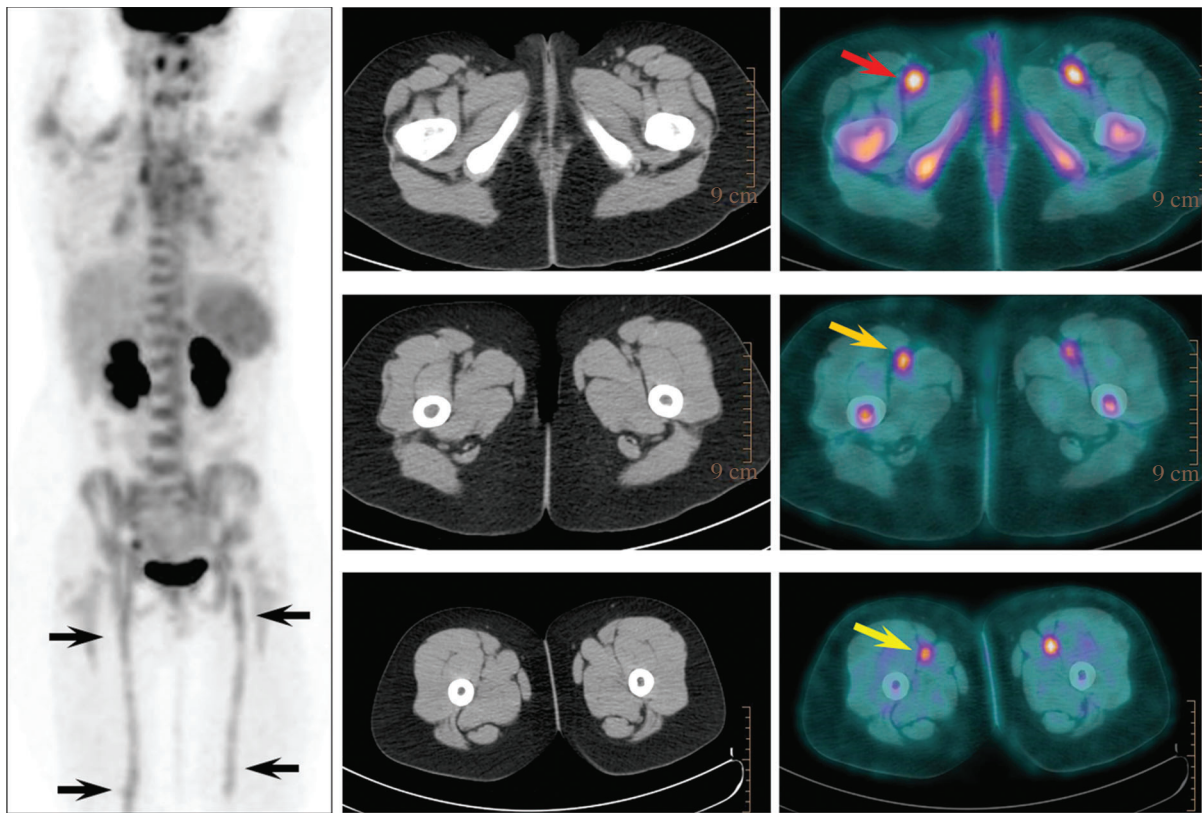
FDG PET-CT images of a teenager with fever of unknown origin. Linear FDG activity in both legs seen on maximum intensity projection (MIP) images (black arrows, left panel) localized to proximal (red arrow), middle (orange arrow) and distal (yellow arrow) femoral arteries on fused PET-CT images (right panel). Arteritis was subsequently confirmed as the cause of his fever of unknown origin.
